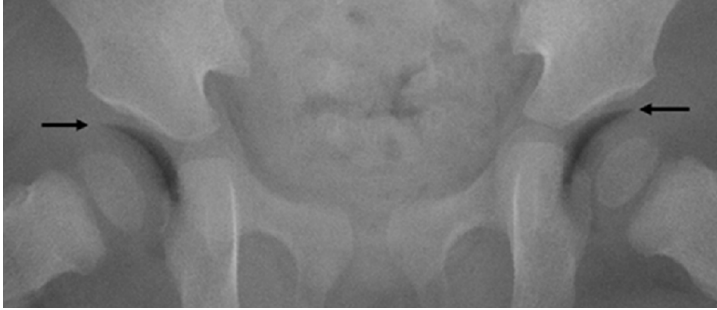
Typical frog-leg-position plain-film radiographic appearance of the vacuum phenomenon in the normal hips of a 2-year-old boy. Note the crescent lucency and the complete type (arrows).
